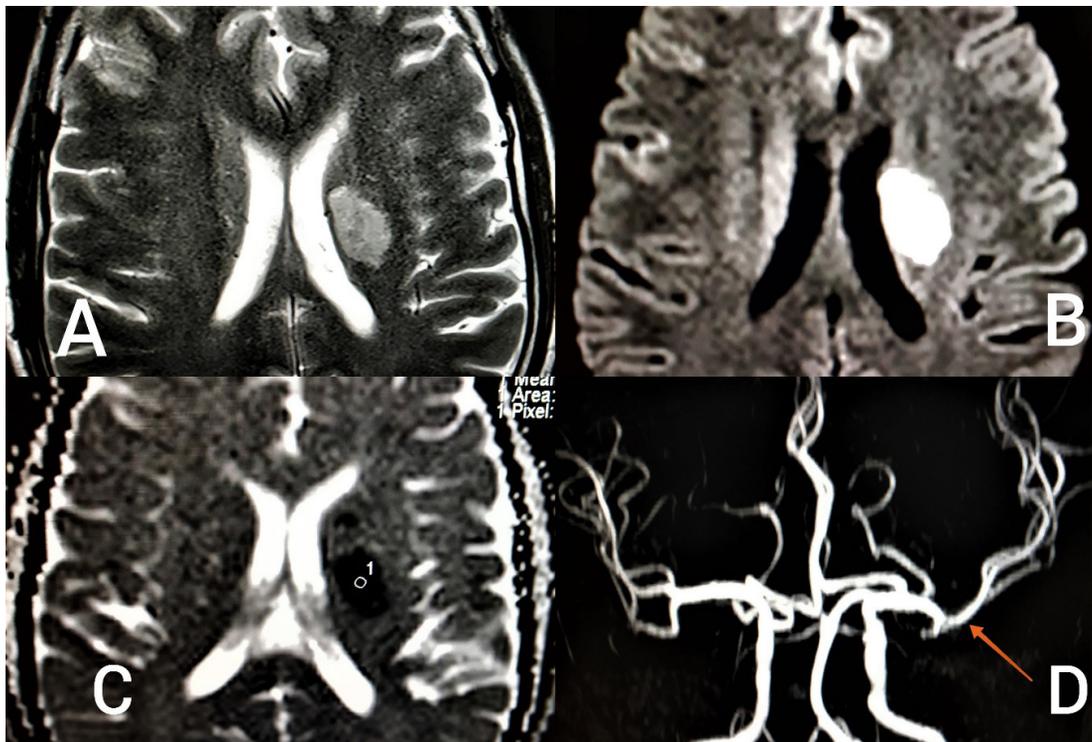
Magnetic resonance imaging (MRI) images, (A) Fluid attenuation inversion recovery (FLAIR) sequence showing corresponding left paraventricular deep white matter hyper-intensity (B) Diffusion weighted sequence (DWI) image and (C) Apparent Diffusion Co-efficient (ADC) map showing restriction in corresponding region of brain. (D) time of flight (TOF) MR angiography sequence showing narrowing of M2 division of left middle cerebral artery (MCA).
